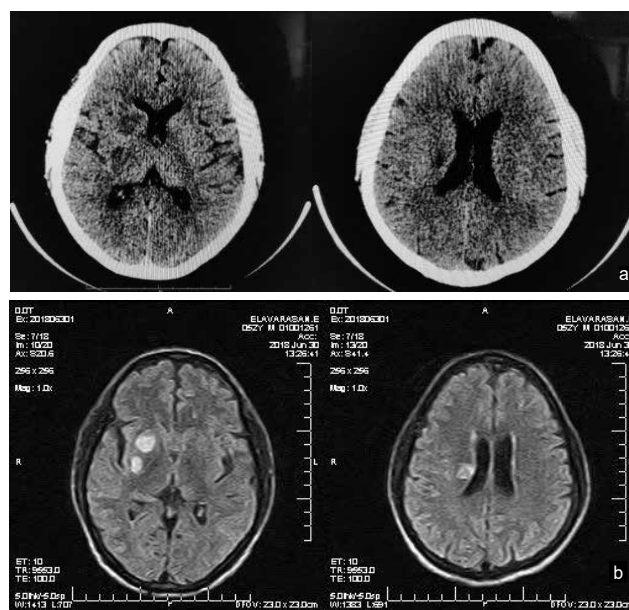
a and b. CT imaging of brain showing two hypodense foci in right caudate nucleus, head of adjacent internal capsule and a focus in right lentiform nucleus and posterior limb of internal capsule (a). MRI showing acute infarct with restricted diffusion in right lentiform nucleus and caudate nucleus (b).
